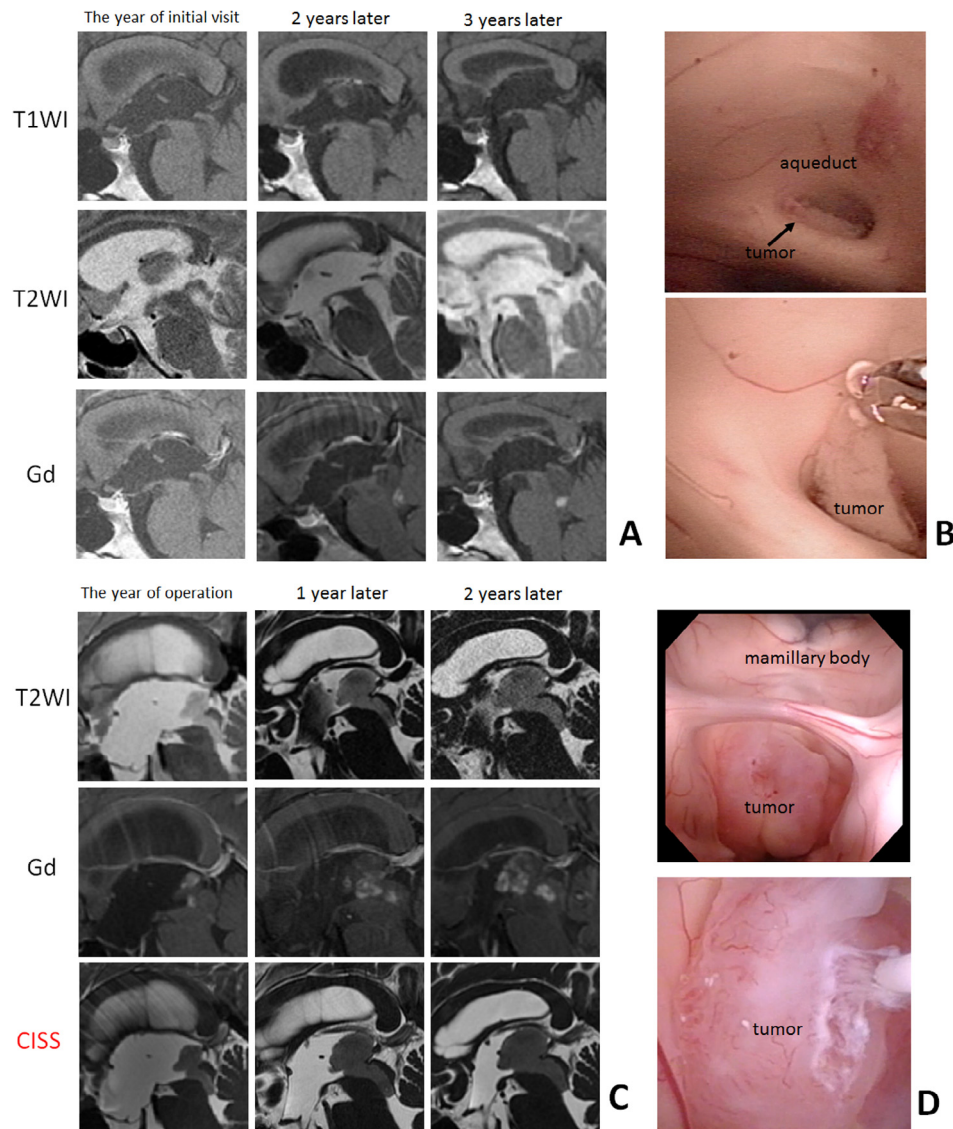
(A) Time-dependent change in Case 1 showed tumor enlargement. The size of tumor was 7.2 mm × 12 mm in the year of initial visit and 9.2 mm × 25.9 mm 3 years later. The attachment of the tumor was not clear, especially by Gd-enhanced image. T1WI and T2WI were helpful; however, it was difficult to make an accurate diagnosis of PAT by only radiographic imaging. (B) The diagnosis of PAT was intraoperatively made. Adhesion to surrounding tissues was strong. (C) Time-dependent change in Case 2 showed tumor enlargement. The size of the tumor was 12.3 mm × 4 mm in the year of initial visit and 37.9 mm × 28.1 mm 6 years later. The attachment of the tumor was not clear, especially by Gd-enhanced image. The diagnosis of PAT was accurately made by CISS. (D) It was intraoperatively observed that the tumor was attached to the aqueduct and it was hardly bleeding.
